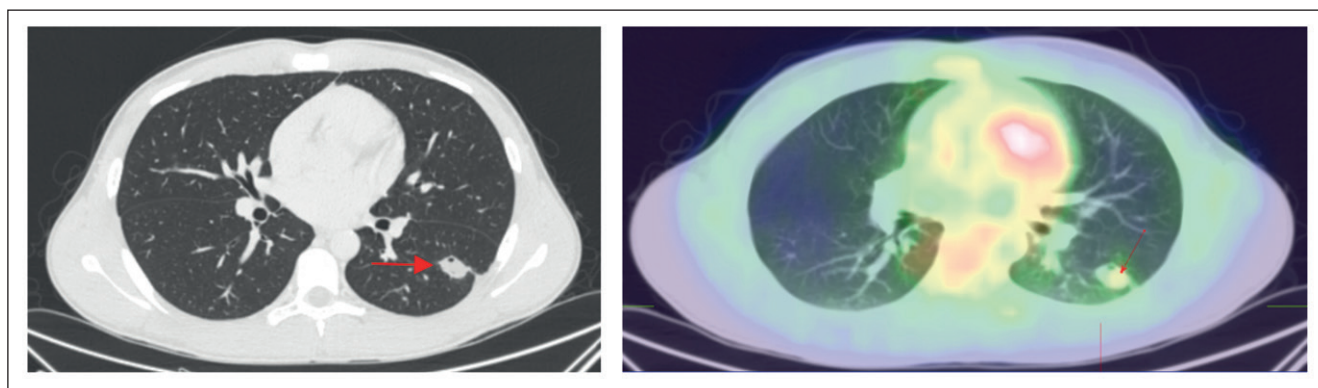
Positron Emission Tomography (PET-CT) after 6 weeks of treatment, where the reduction of the images is evident, with less metabolism.
